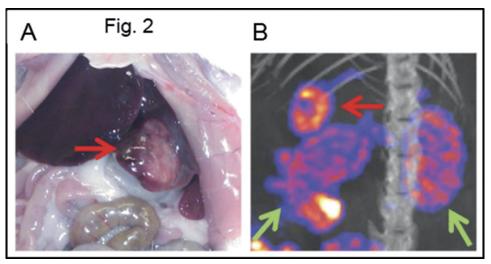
(A) Intrahepatic CA20948 tumor 10 days after inoculation. (B) ¹¹¹In-DTPAOC uptake in an intrahepatic CA20948 tumor visualized by micro-SPECT/CT. Red arrow, intrahepatic CA 20948 tumor; green arrows, kidneys.
